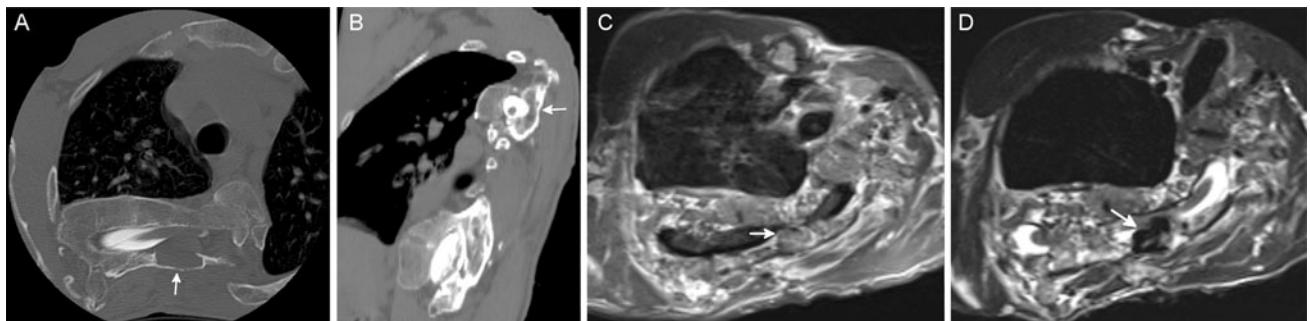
Pre-operative images depicting the lesion. Arrows point to the lesion. a Axial CT myelogram, b sagittal CT myelogram, c T1-weighted axial MRI, d T2-weighted axial MRI
